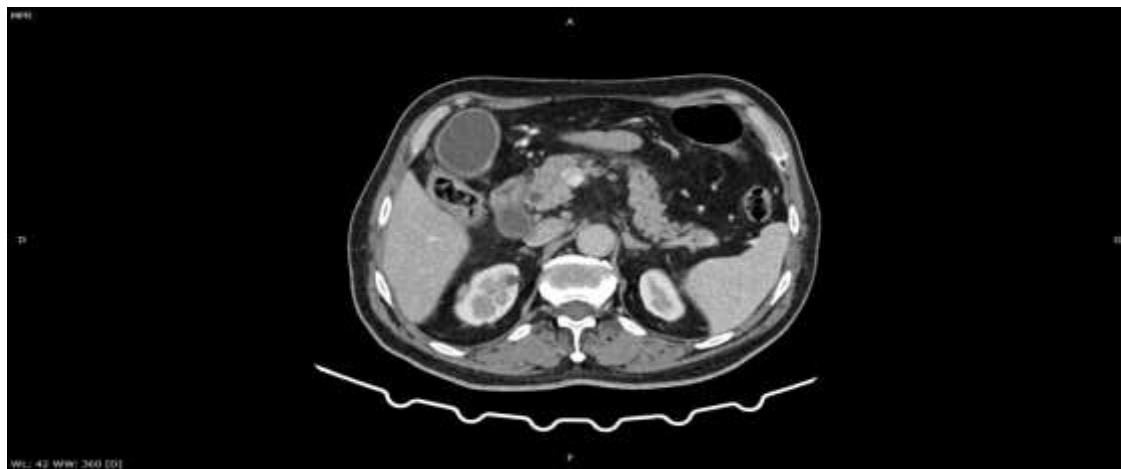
Abdominal CT scan showed stage A pancreatitis. (figure 2)
